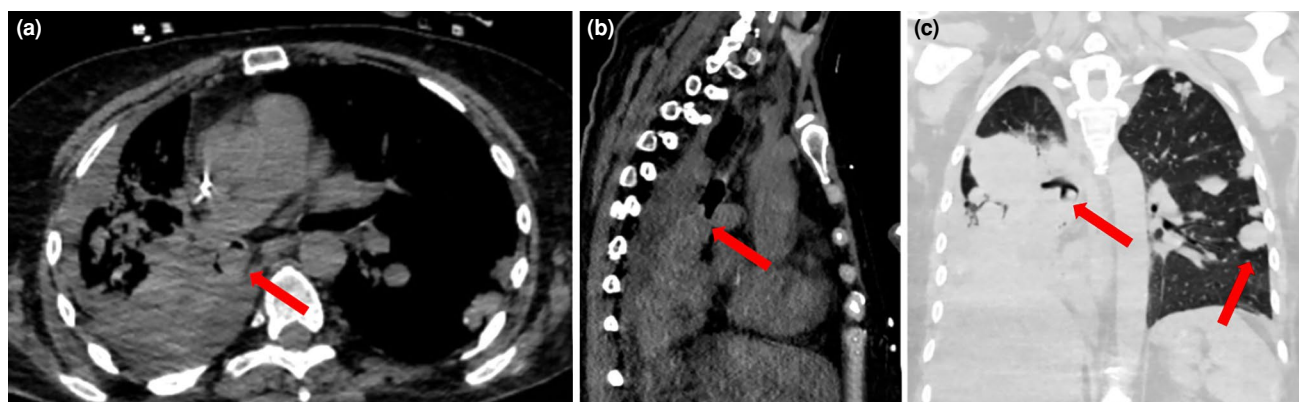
Chest CT demonstrating an intraluminal lesion causing significant airway obstruction. (a) Axial CT image reveals a hyperdense endobronchial mass occupying the bronchial lumen (red arrow). (b) Sagittal reconstruction shows the longitudinal extent of the lesion along the airway (red arrow). (c) Coronal image demonstrates both the obstructing endobronchial mass in the right bronchus and multiple parenchymal metastatic lesions in the contralateral lung (red arrows).
